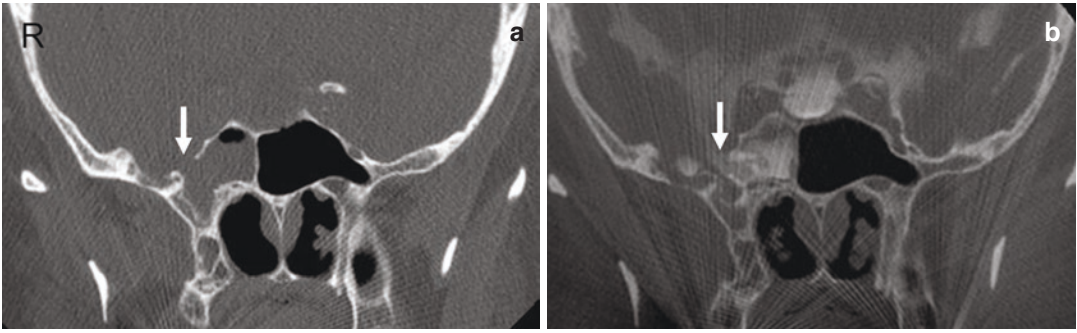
CSF leak. (a) Coronal CT image shows a bony defect of the right sphenoid sinus (arrow). (b) Coronal CT image from a cisternogram shows leakage of contrast into
